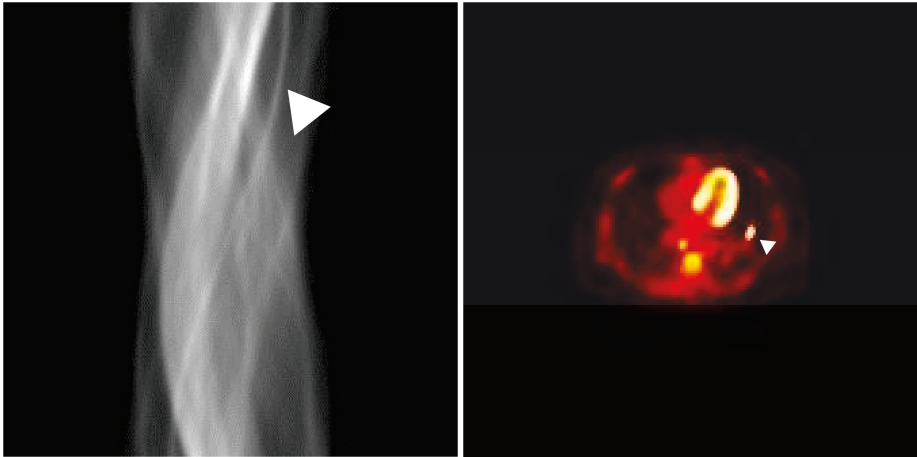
(Left) Sinogram from a single slice from a thorax acquisition study with  $^{18}\text{F}$ FDG. (right). Slice reconstruction from the previous sinogram. The white triangle pinpoints the location of a tumoral lesion both in the sinogram and the reconstructed image. It can be clearly seen that this point-shaped lesion traces a sinusoidal trajectory. Image courtesy of Cristina Chavarrias.
